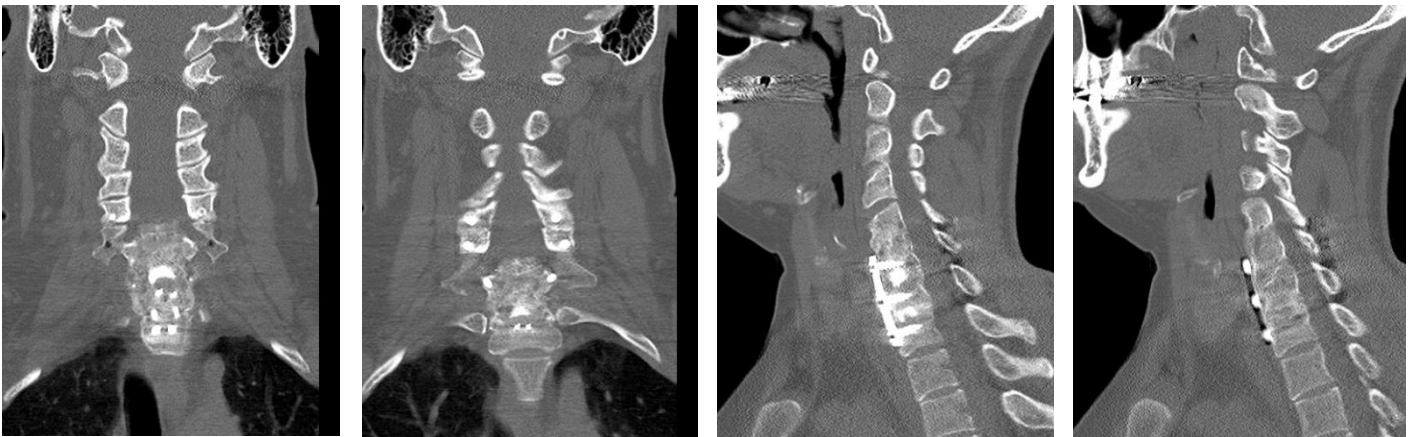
CT at 6 month follow up showing fusion from C5-T1.
